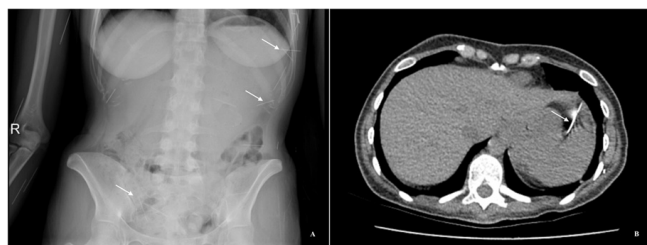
Case 1. Plain radiograph figure (A) and axial computed tomography figure (B) on admission day show multiple sewing needles (white arrows) both in intraabdominal cavity and adjacent structures
